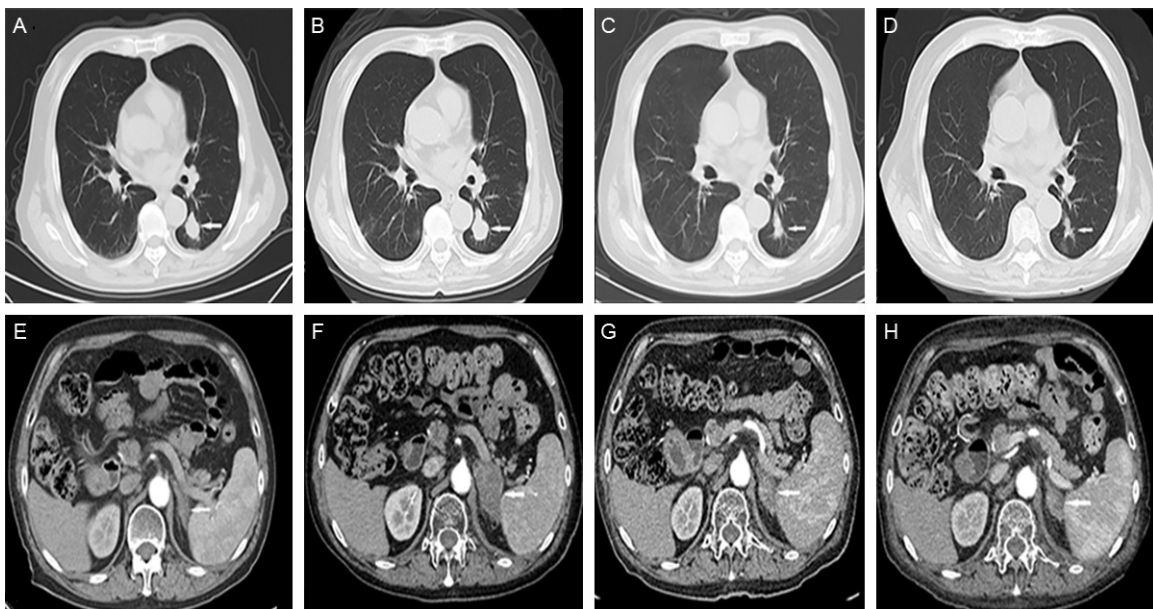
Response evaluation. A, E: Lung metastases and no adrenal gland metastases identified by CT on January 2014; B, F: Lung metastases progressed and left adrenal gland metastases newly identified on March 2014, before the pemetrexed treatment; C, G: After 2 cycles chemotherapy, both lesions were remission on April 2014; D, H: The tumor was still partial remission after 6 cycles chemotherapy.
